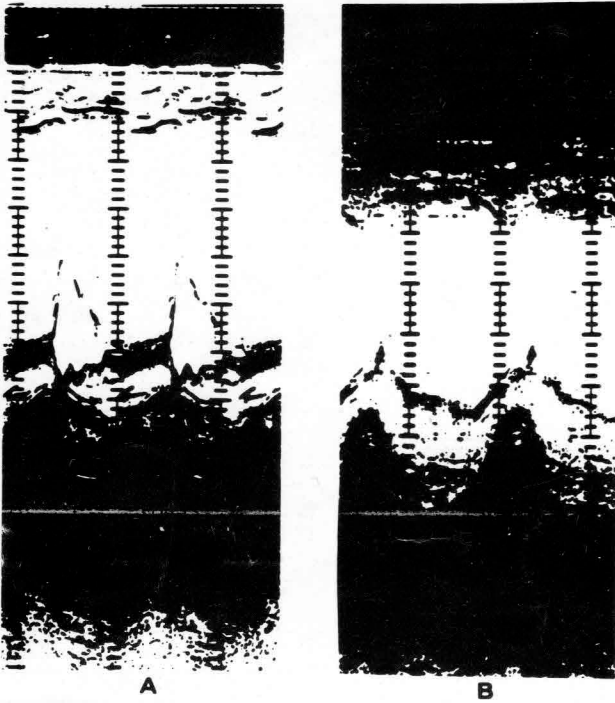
M-Mode echocardiogram during tachycardia (A) and during sinus rhythm (B). Normalization of the ventricular dimensions and improvement of the wall motion after restoration of the sinus rhythm is observed.
